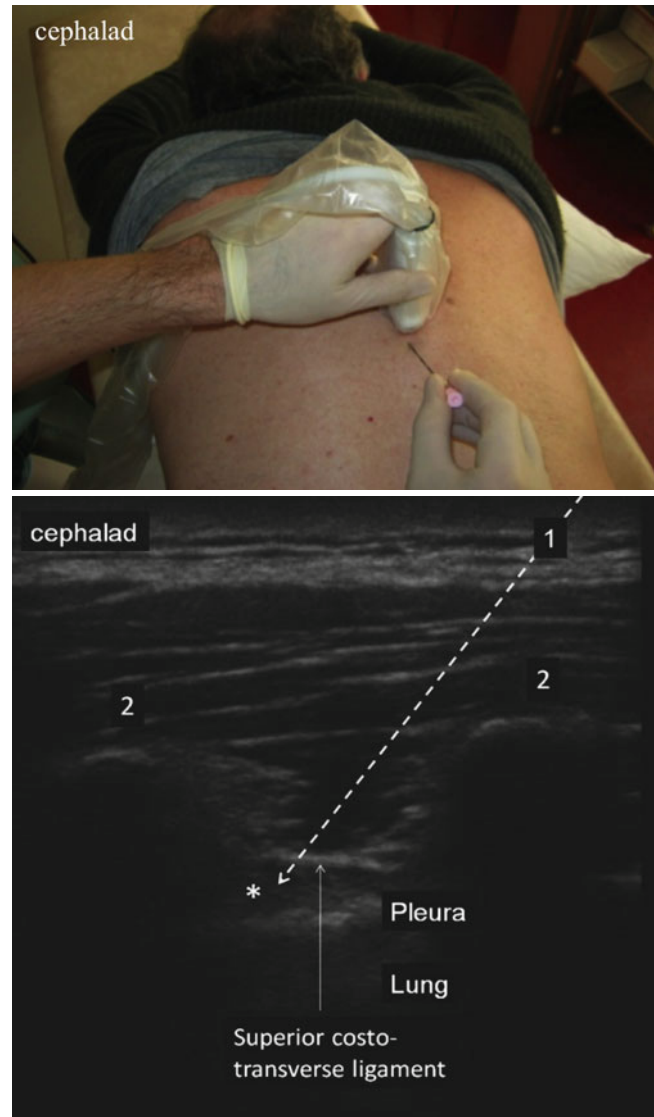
Ultrasound injection of the intercostal space, from horizontal orientation. *1* needle, *2* rib (Images courtesy of Róbert Rapčan, MD)
